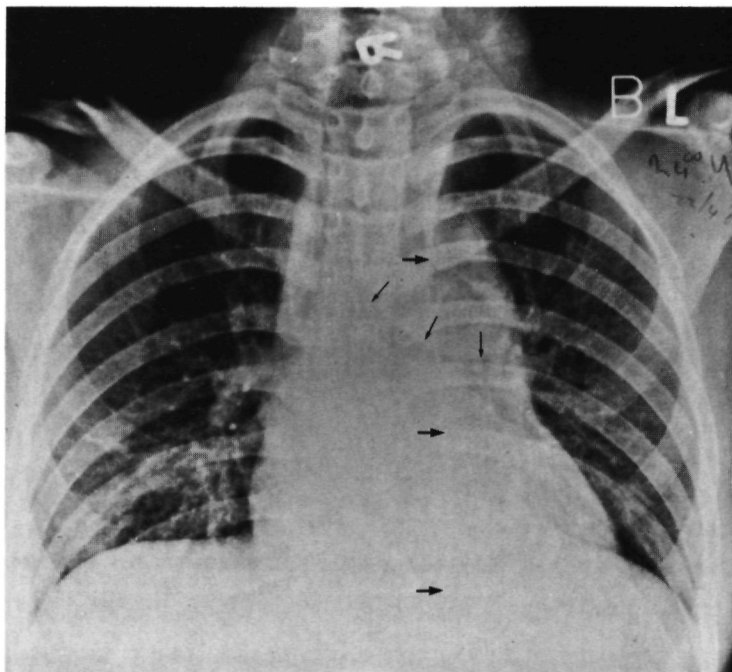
8 Female, 22 years, car-driver, TAR. Uneventful recovery after operation. Chest X-ray: widened left paraspinal line (arrows). Widening of the mediastinum (10 cm). Slight displacement of the trachea and left main bronchus (arrows), widened paratracheal line.
